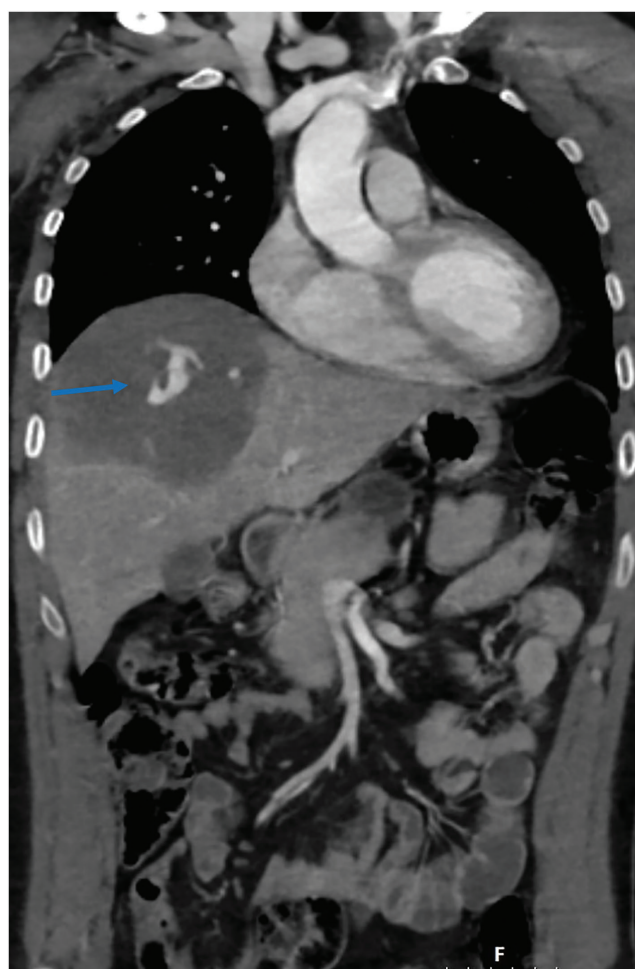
CTA performed in the emergency setting revealed active extravasation in the liver (arrow).
